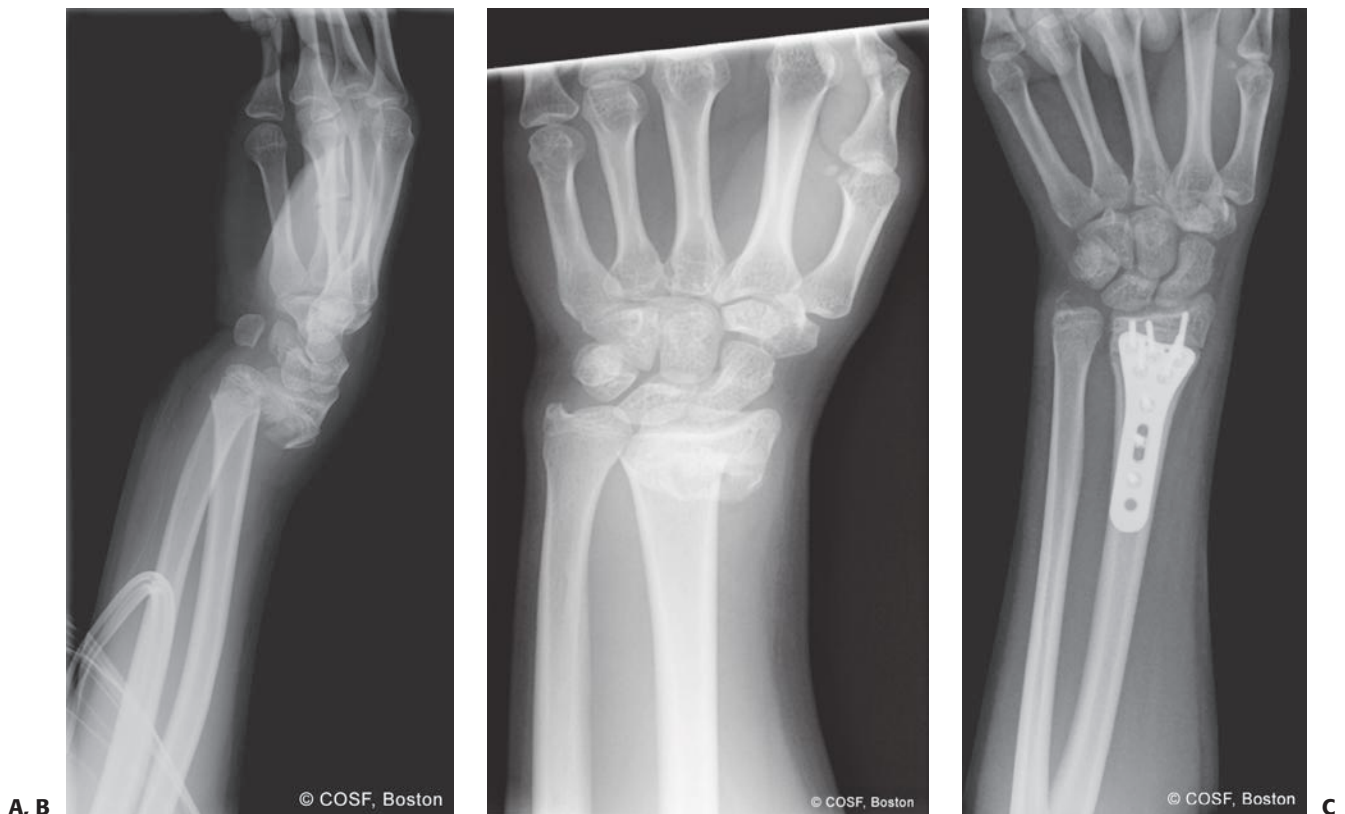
A, B: AP and lateral radiographs of a 14-year-old skeletally mature female with a displaced extra-articular fracture. C, D: This fracture was treated with a fixed-angle volar locking plate, with distal screws crossing the physis. The long-term effects of this type of fixation are unknown.
